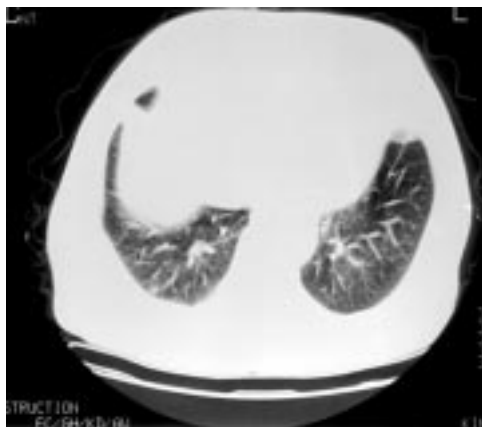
Computed tomogram of the thorax.
